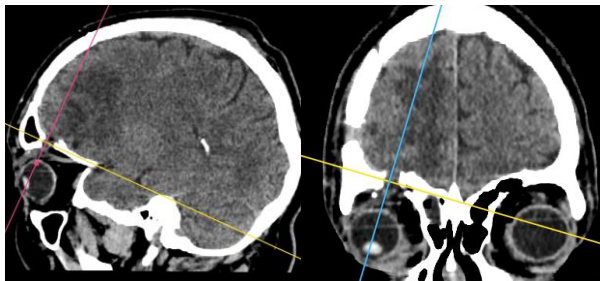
Postoperative CT demonstrating regression of cerebral edema and reduction of the abscess cavity.
